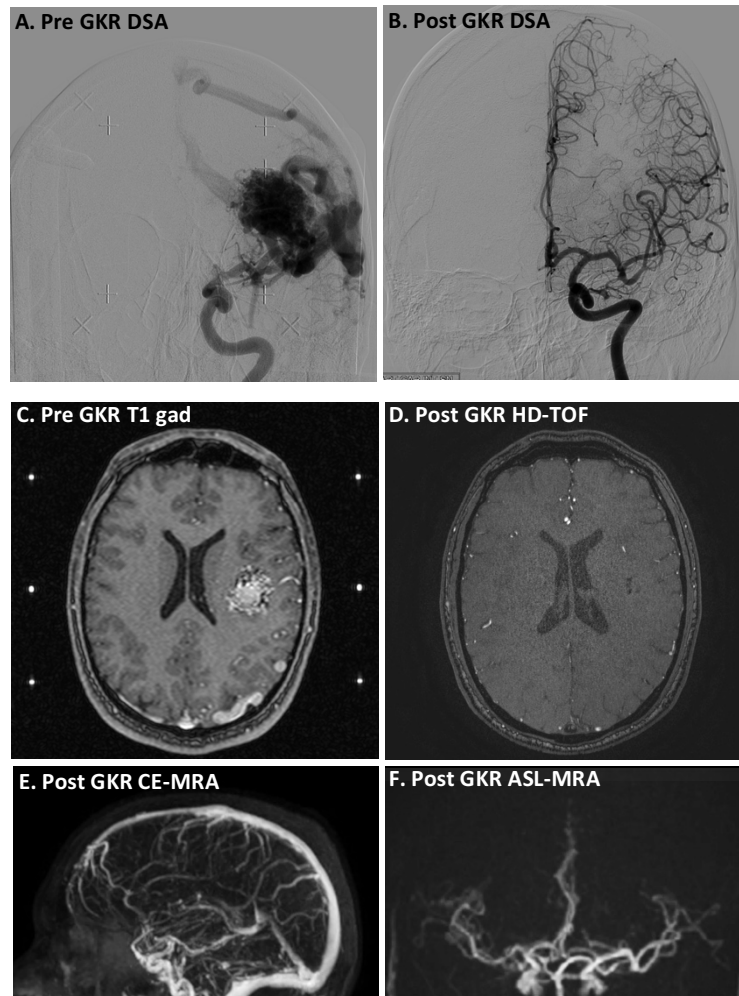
Representative example of DSA and triple-MRA datasets presented to the independent observers for review in a case with complete AVM obliteration. DSA (top row) and triple-MRA series (C-E) were reviewed in different sessions. The stereotactic DSA performed on the day of GKR (A, note fiducial crosses) was available to the observers and it served as an aid for the assessment of follow-up DSA (B). Similarly, the stereotactic T1 MRI with contrast (C, note stereotactic fiducial markers) was used as a guide for the evaluation of triple-MRA, which included HD-TOF (D), CE-MRA (E) and ASL-MRA (F). No residual nidus or AV shunt is noted in any of the post GKR images.
